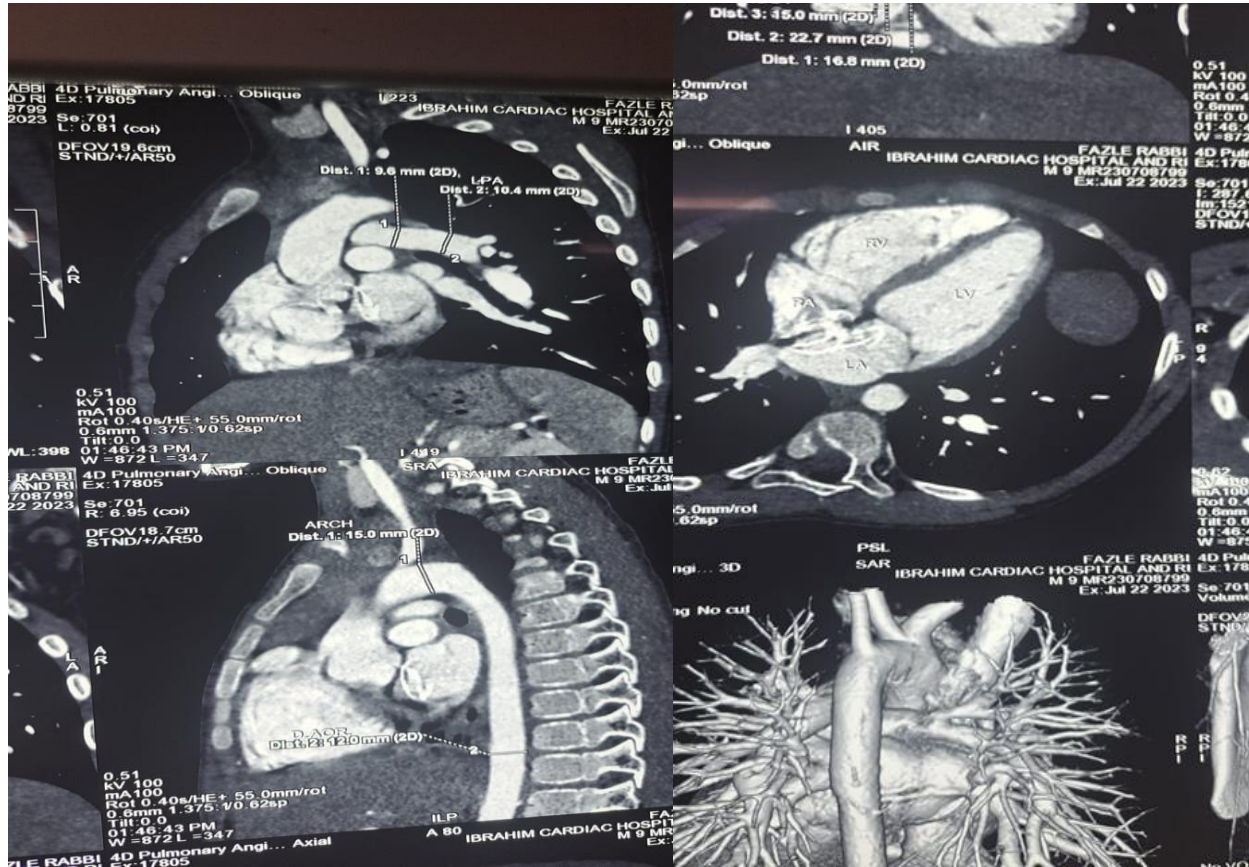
Cardiac CT angiogram showing LPA stenosis
